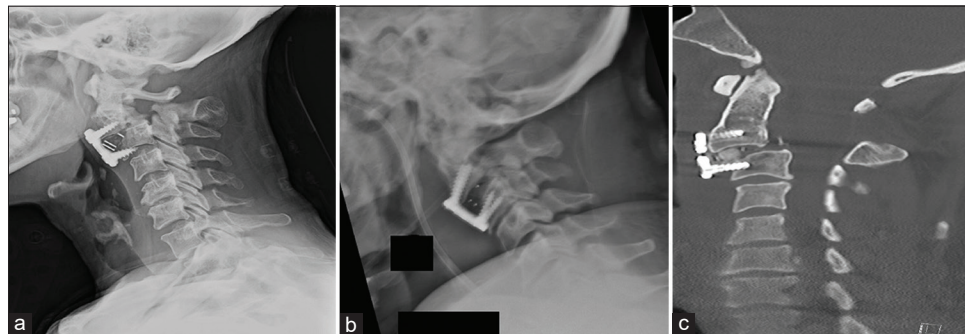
C-spine X-ray [lateral] shows (a) C2-3 arthrodesis with new anterolisthesis, (b) C2-3 arthrodesis with new anterolisthesis, (c) CT C-spine [sagittal] shows new C2-3 anterolisthesis.
